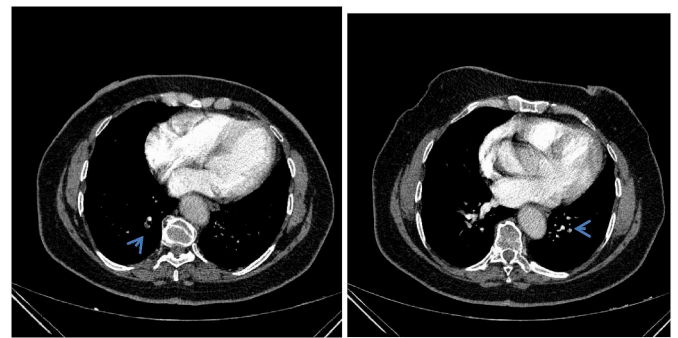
73-year-old woman with two weeks of all-day continuing cough. CT pulmonary angiography shows pulmonary emboli in bilateral lower lobe artery (arrows).
